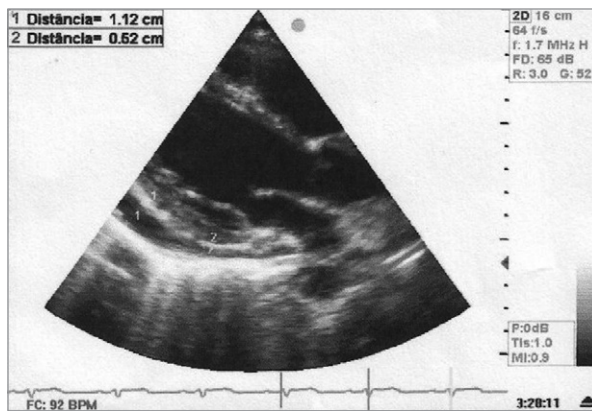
Transthoracic echocardiogram shows pericardial effusion.
